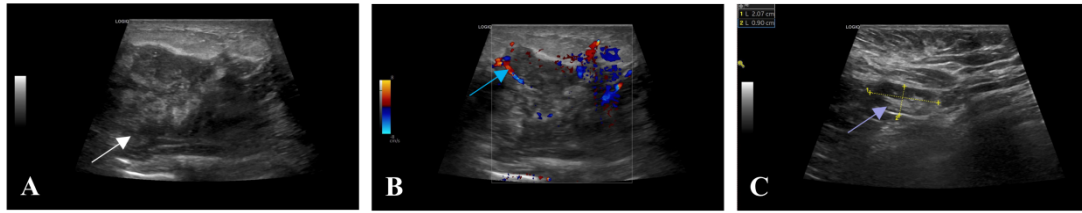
Ultrasound images. (A) Left-breast grayscale ultrasound images demonstrating a heterogeneous lesion (white arrow), (B) Left-breast Color Doppler Flow Imaging (blue arrow), (C) Enlarged lymph nodes in the left axilla (purple arrow).
